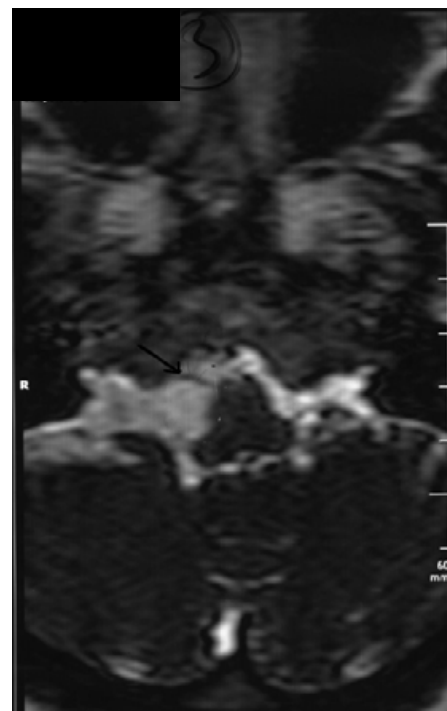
Axial T2W-3D Drive sequence in the temporal MRI of a 32-year-old man. The right hypoglossal nerve is certainly visualized.
